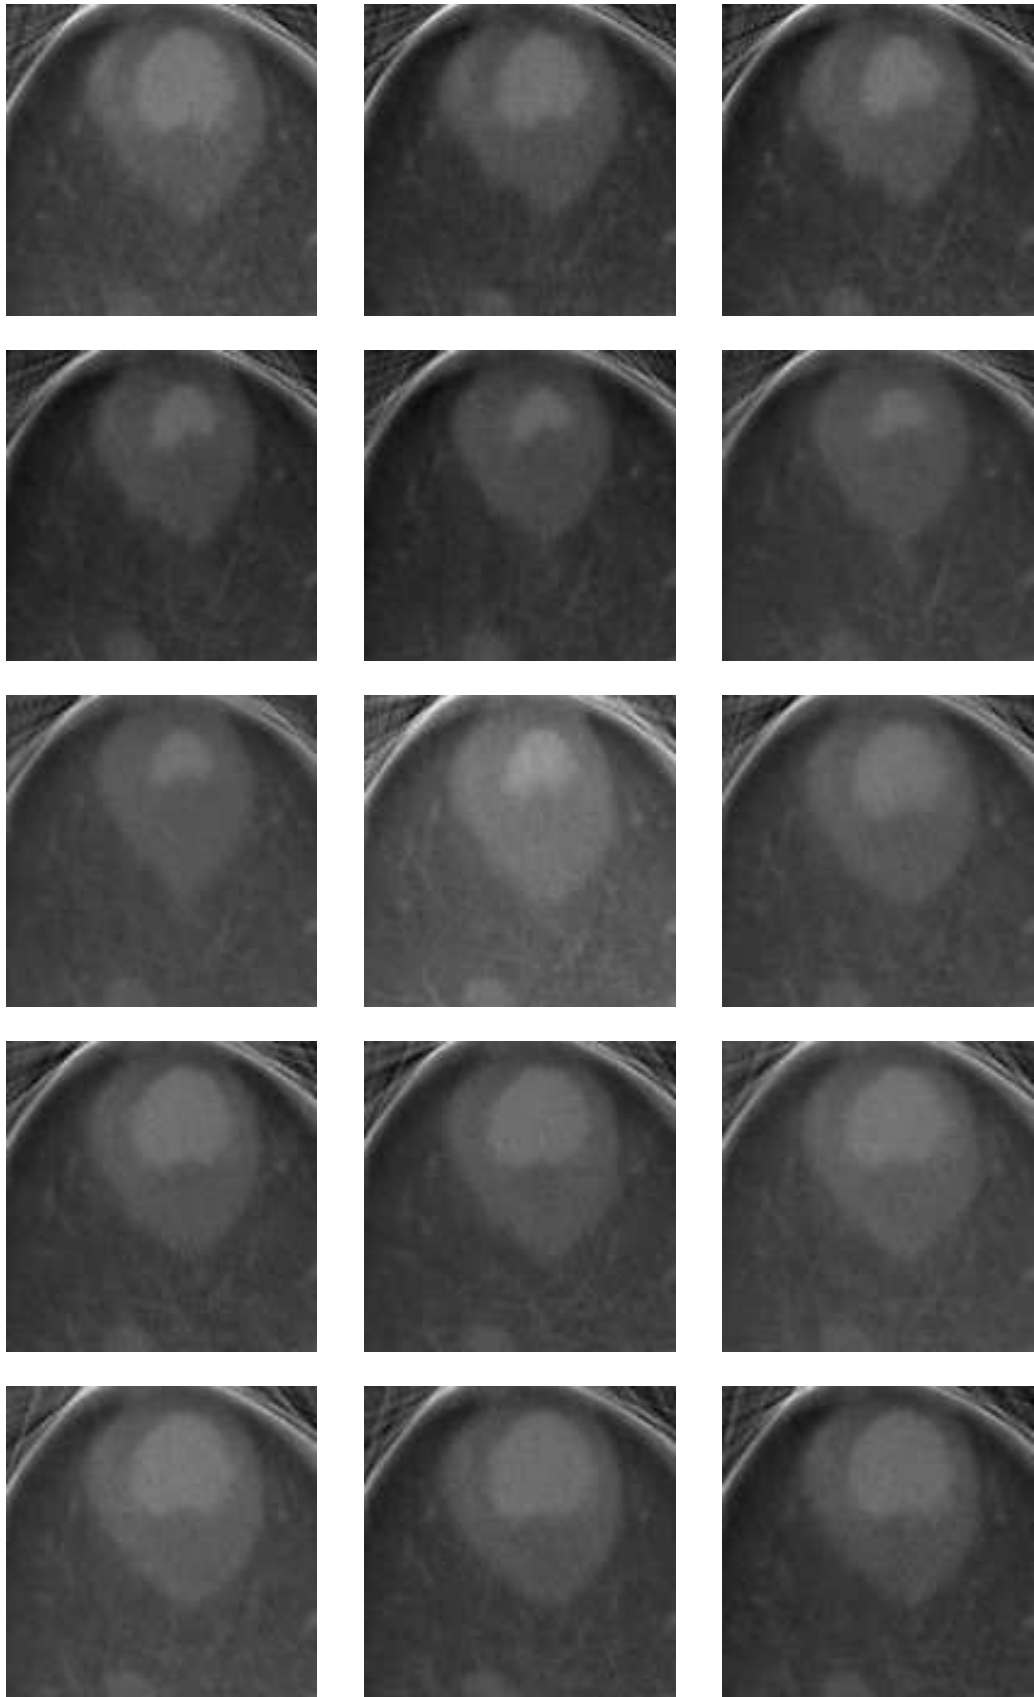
Samples of CT cardiac image over a cardiac cycle [1].
